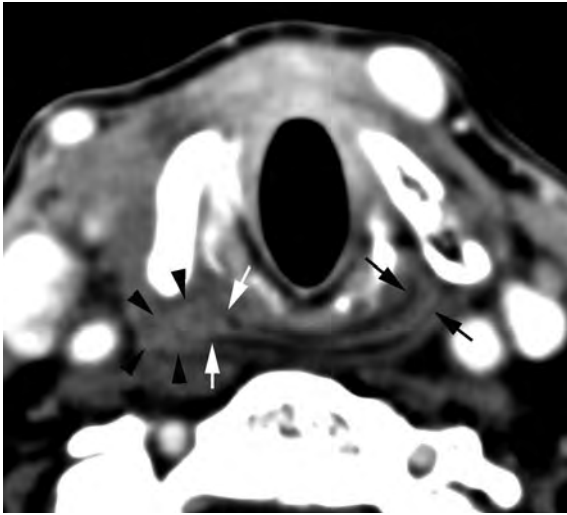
Axial contrast-enhanced CT image through the post-cricoid region shows normal submucosal fat planes on the left (black arrows) and abrupt cutoff of the submucosal fat planes on the right (white arrows) caused by a small pyriform sinus tumor on the right (arrowheads)
